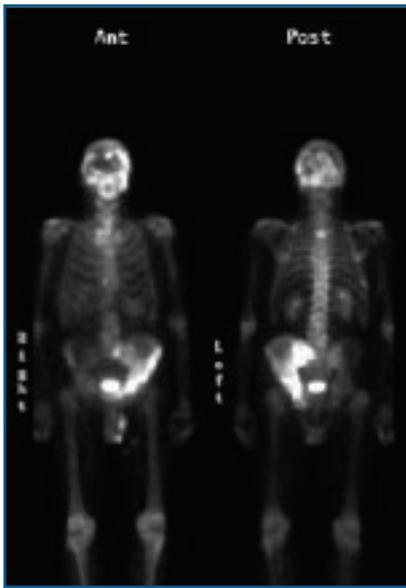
Isotope bone scintigraph demonstrating Paget's affecting the left hemi-pelvis and skull.
